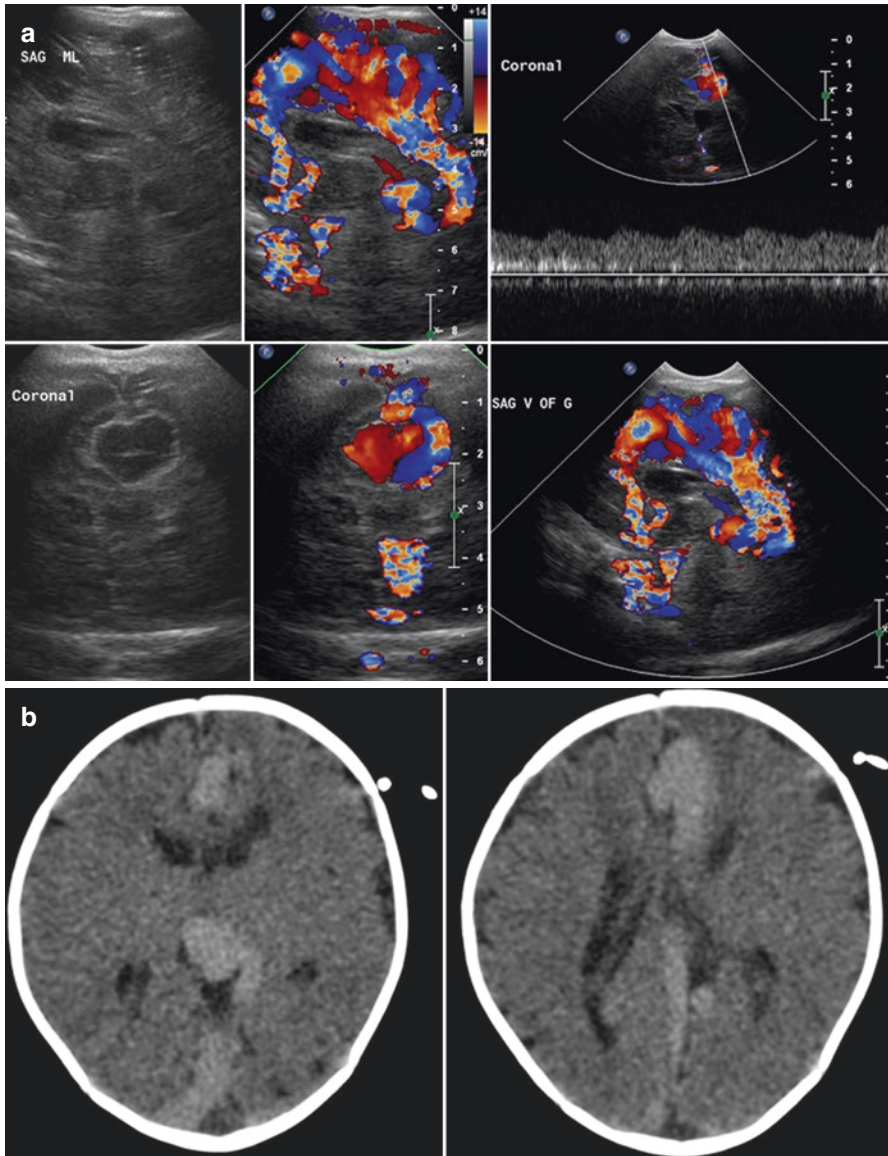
One-month-old girl with a complex left frontal parasagittal arteriovenous fistula with multiple large feeding arteries and diffuse moyamoya like collateral supply. Direct arteriovenous shunting into an enlarged midline supracallosal vein, which drains into an aneurysmally enlarged vein of Galen. Sagittal and coronal US images including color-coded duplex sonography (a) reveal a significantly dilated anterior cerebral artery, which drains into a dilated vein of Galen. Significant turbulence and a propagated arterial waveform are noted within the vein of Galen. Axial non-contrast enhanced CT (b) shows the mildly hyperdense, elongated and tortuous draining vein within the midline. No intracranial hemorrhage or focal stroke is seen. Multi-sequence MR (c) including coronal and axial T2, sagittal T1, axial source MRA, sagittal MIP MRV, and axial SWI MR images allow to localize and characterize the vascular malformation in detail. Coronal and sagittal MRA and contrast enhanced dynamic MRA and MRV (d) display the various feeding arteries and draining veins. The 3D TOF MRA shows the arterial side in detail, the contrast enhanced MRA and MRV show the draining veins in better detail. Both studies are complementary. Conventional DSA in lateral and anterior-posterior projection (e) confirm the complex angio-architecture of the vascular malformation as seen by MRA and MRV
